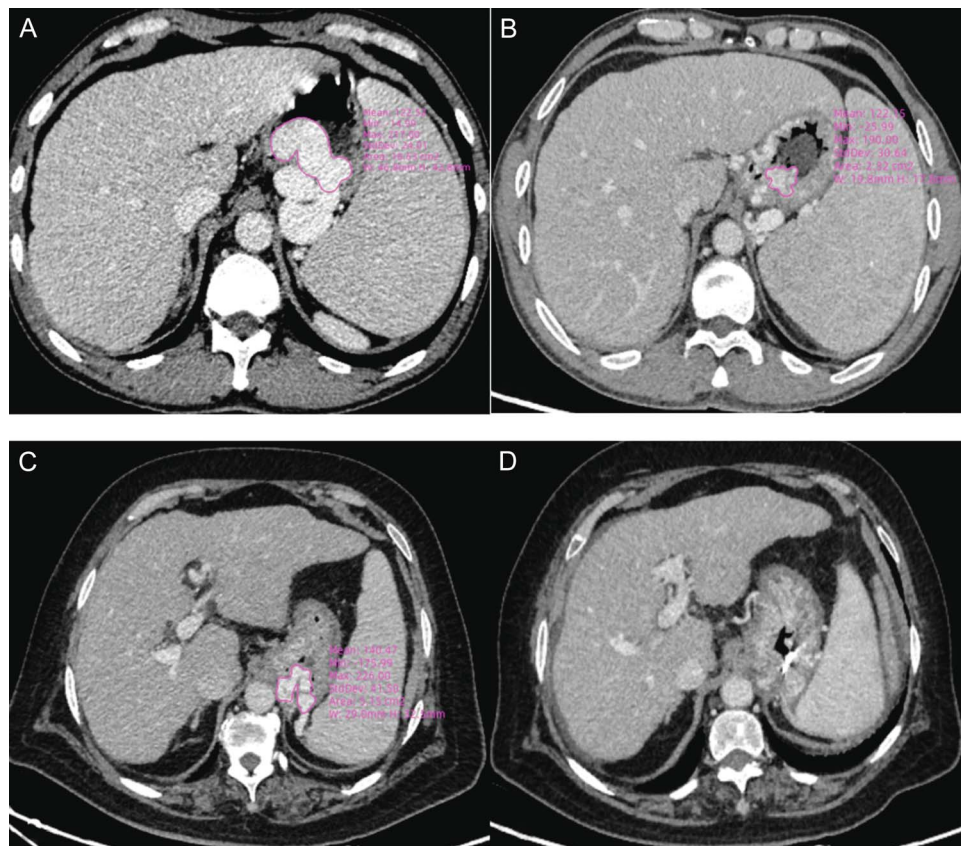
Measurement of IGV1 obliteration rate and cyanoacrylate embolization efficiency under abdominal CTA. First patient: (A) Preoperative CTA revealed a large GV, with the maximum cross-sectional area of the GV within the gastric wall measured at 10.63 cm². During surgery, 4.5 mL of cyanoacrylate was injected. (B) Postoperative CTA monitoring showed a reduction in variceal area with a measured value of 2.32 cm². Therefore, the IGV1 obliteration rate was calculated to be 78.17% and the embolization efficiency of cyanoacrylate to be 1.85 cm²/mL. Second patient: (A) Preoperative CTA showed a tortuous GV, with the maximum cross-sectional area of the GV within the gastric wall measured at 5.15 cm², and 1.5 mL of cyanoacrylate was injected during surgery. (B) Postoperative CTA monitoring showed complete disappearance of the GV, with residual titanium clips present. Therefore, the IGV1 obliteration rate was 100%, and the embolization efficiency of cyanoacrylate was 3.43 cm²/mL. CTA: Computed tomography angiography; GV: Gastric varices; IGV1: Isolated gastric varix type I.
